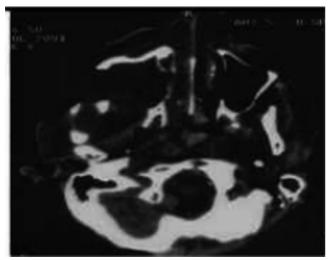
CT scan showing intense osseous destruction.
